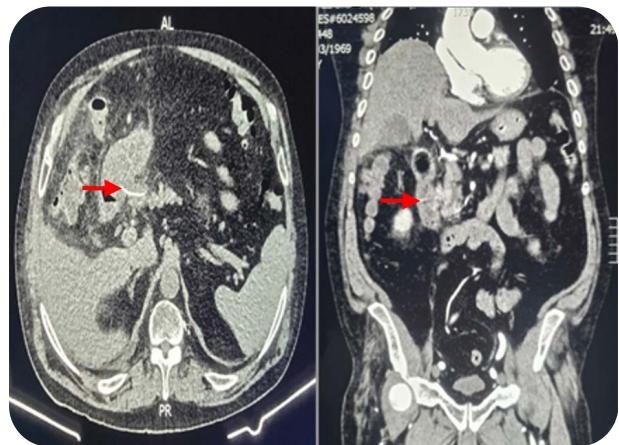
Coronal and axial CT. (red arrow) Foreign body which punctures the duodenum's inner wall towards the pancreas.
